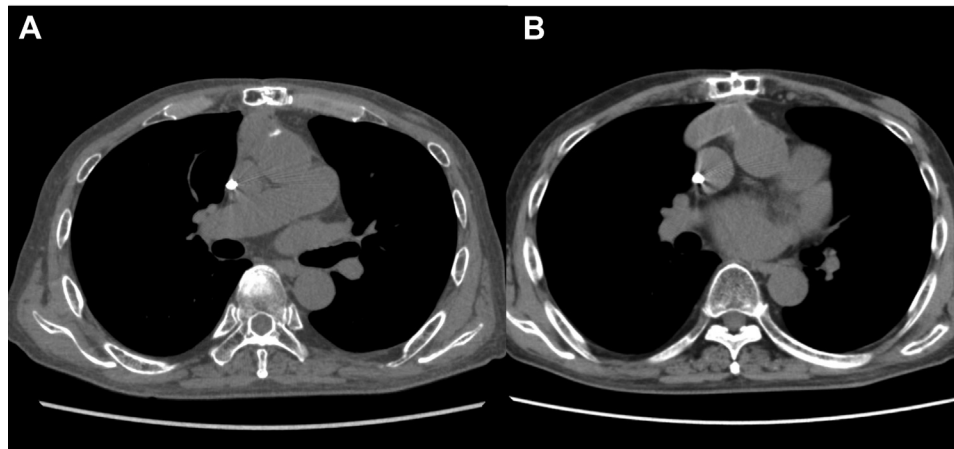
Follow-up CT images at 13 months after the initiation of PORT. (A) No evidence of cancer recurrence was observed. A soft tissue mass can be noted in the tumor bed. This mass revealed no change in size from immediately after the surgery until this CT, leading to its diagnosis as a postoperative scar. (B) No significant change was noted around the graft or anastomotic region. CT, computed tomography; PORT, postoperative radiotherapy.
